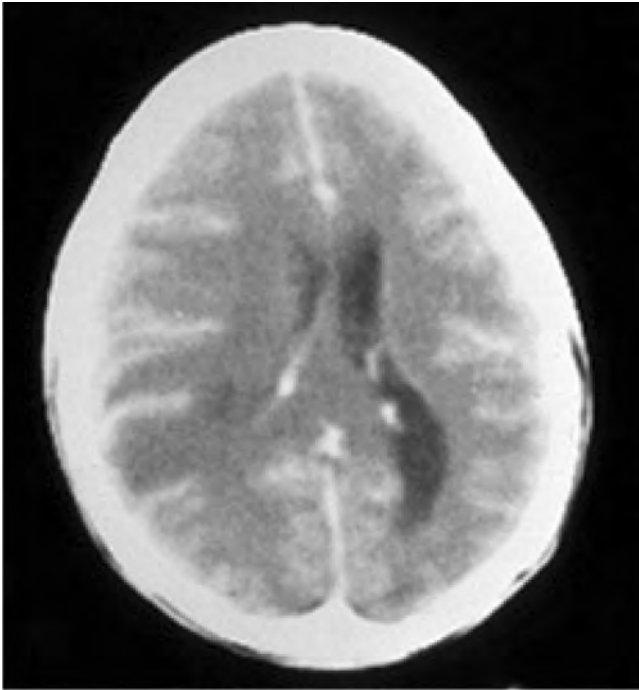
Acute necrotizing haemorrhagic leucoencephalitis. Diffuse oedema predominantly in one hemisphere (CT scan).
